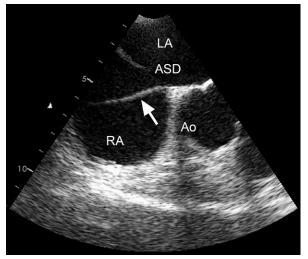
Transesophageal echocardiogram shows a membrane (arrow) dividing the right atrium.
